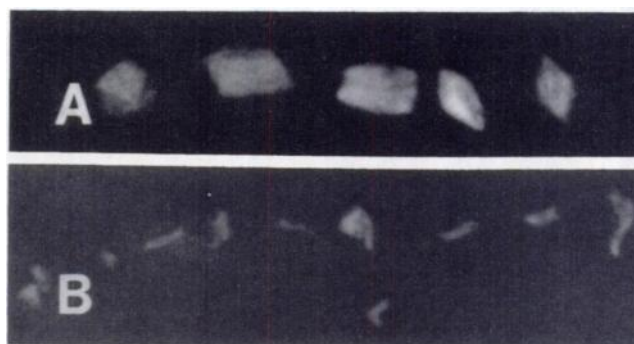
Radiographs of Gelfoam pledgets in vitro. A, Gelfoam pledgets (original size  $2 \times 2 \times 2$  mm) after being soaked for  $\frac{1}{2}$  hr in liquid iophendylate (Pantopaque). B, Same pledgets of Gelfoam after being extruded through Medi-tech catheter. Gelfoam is now broken up into pieces about size of catheter orifice. They have retained dense radiopacity. (Photograph reproduced to same scale as A.)
